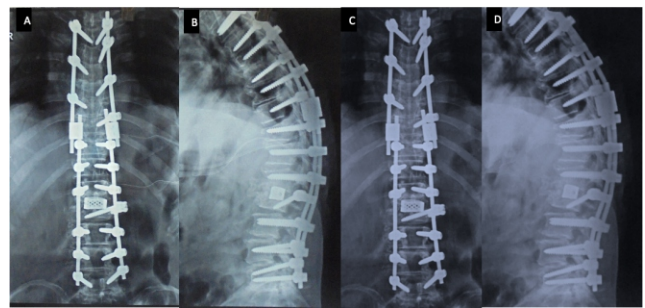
(A, B) 3rd surgery post-operative radiograph with extension of screw construct on the PLRT rod (PLRT-presumptive elongated rod technique). Previous surgical area was not opened. (C, D) 13 months follow-up radiograph with stable reconstruct and favourable patient reported outcome.
